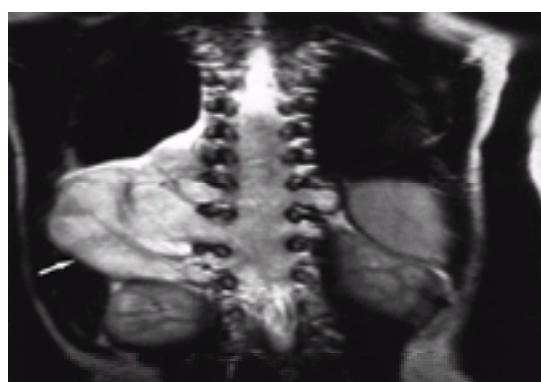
Coronal, T_2 -weighted, fast spin, echo MRI image showing a large right adrenal neuroblastoma (arrow) with extension into the spinal canal.
